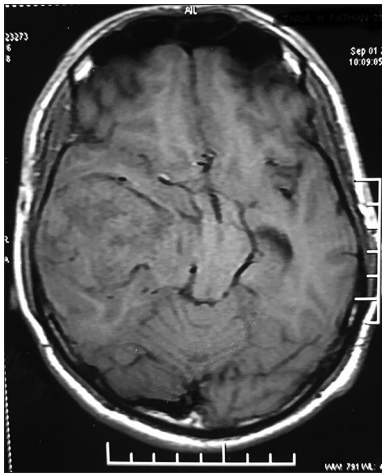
Preoperative T1-weighted image showing isointense lesion in the right middle cranial fossa
